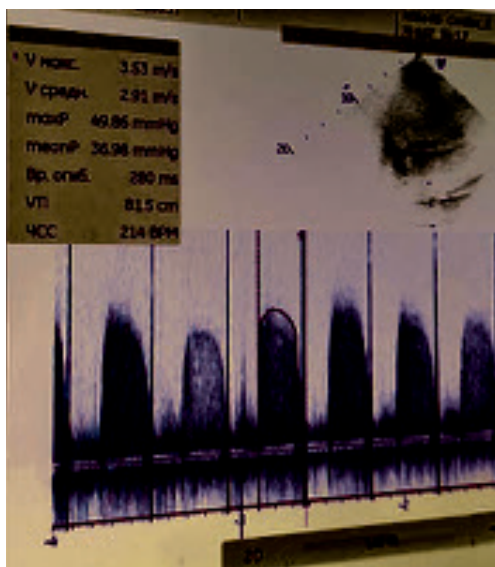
Transthoracic echocardiography before intervention
